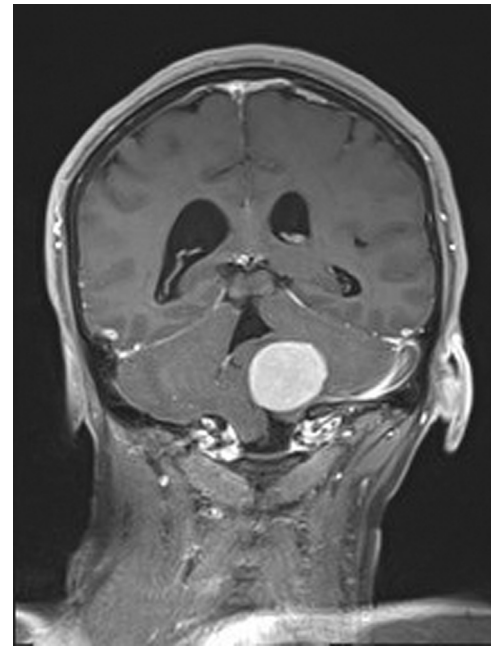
T1 coronal-weighted magnetic resonance imaging with contrast demonstrating right tonsillar herniation.
